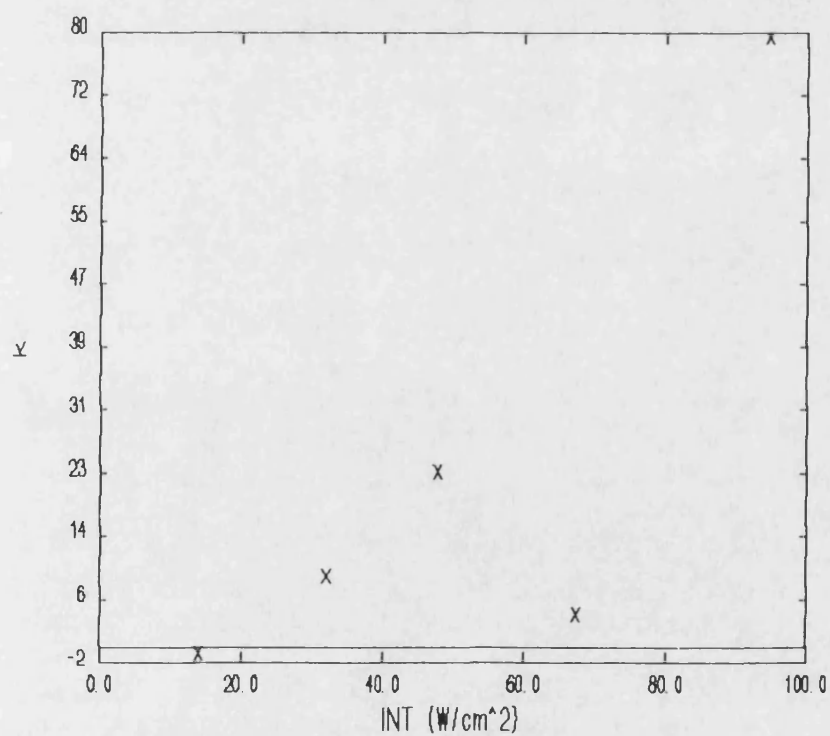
Effect of ultrasonic intensity on the Berlin rate constant
